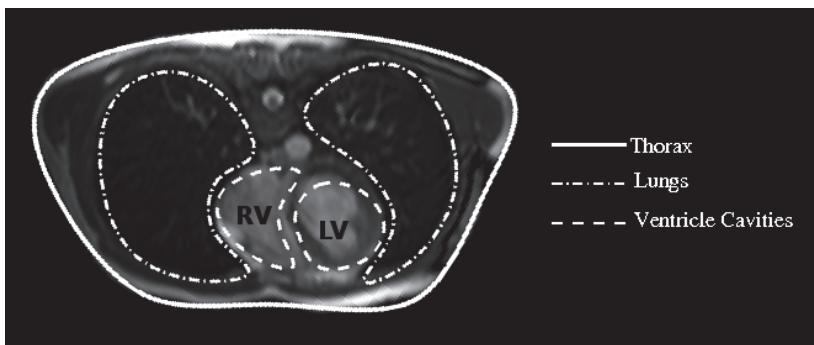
Manual segmentation of an MR image. The boundaries of the lungs, ventricle cavities and thorax are represented by splines. LV and RV denotes left ventricle and right ventricle, respectively.
